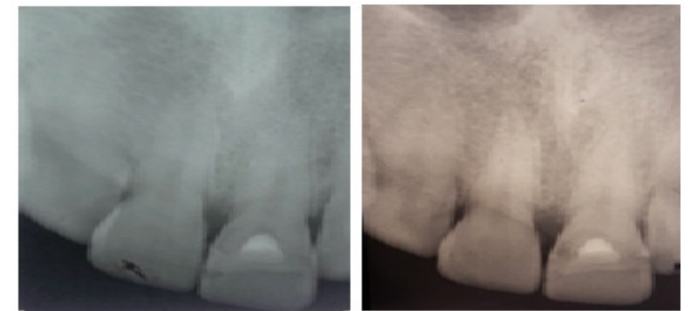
3-month (A) and 12-month (B) follow-up radiographs.
